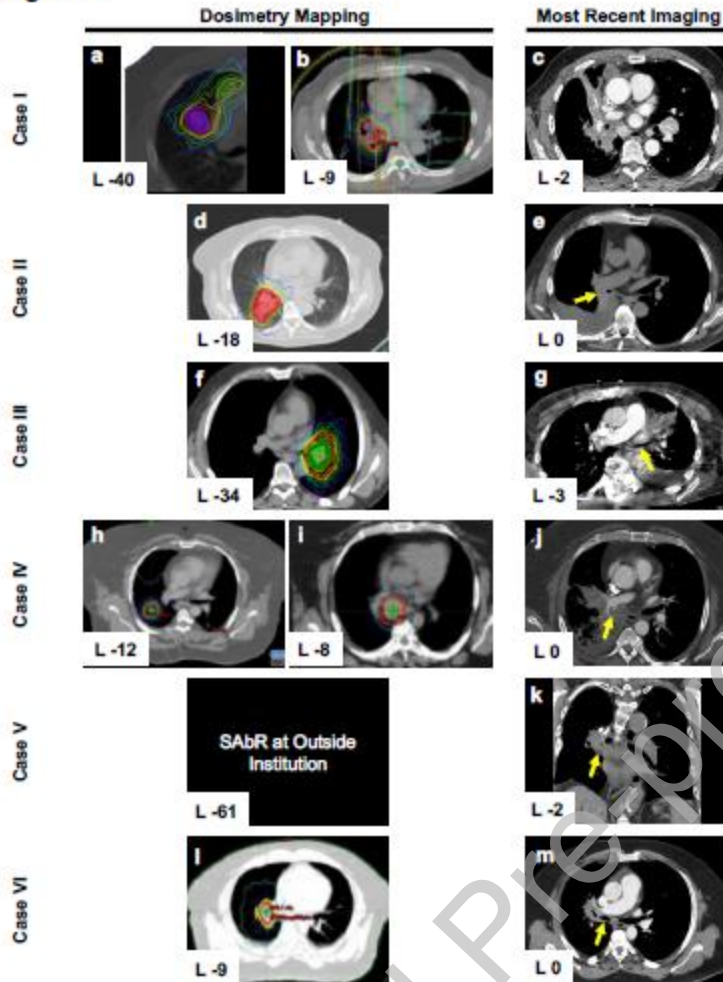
Integrated SABR dosimetry mapping and chest imaging preceding massive hemoptysis. Axial and coronal images of the cases with time in months from image to development of life-threatening hemoptysis (insert [L-months]). *Case I.* (a) Dosimetry mapping of planned SABR for 1.7cm right lung nodule and 2.7cm mediastinal lesion. (b) Dosimetry mapping for planned SABR to 2cm right hilar mass. (c) CT chest with IV contrast 2 months prior to LTH showing right bronchial obliteration and endobronchial lesions. *Case II.* (d) Dosimetry mapping of planned SABR for a 4.8cm right infrahilar mass. (e) CT chest on day of LTH revealing right bronchial constriction (arrow). *Case III.* (f) Dosimetry mapping of planned SABR for 3.1cm left hilar mass. (g) CT angiogram of the chest 3 months prior to LTH showing radiation fibrosis, bronchial narrowing (arrow), and ectatic vessel formation. *Case IV.* (h) Dosimetry mapping of planned SABR to a 1.5cm RUL mass. (i) Dosimetry mapping of planned SABR to a 3.6cm subcarinal lymph node. (j) CT angiography on the day of hemoptysis revealing a 7mm pseudoaneurysm (arrow) originating from the right intralobar pulmonary artery. *Case V.* Dosimetry mapping unavailable. (k) CT chest 2 months prior to LTH revealing a bronchial mass (arrow) leading to obstruction of multiple right lung segments prompting bronchoscopy. *Case VI.* (l) Dosimetry mapping of planned SABR to a 3.3 cm R hilar mass prior to SABR. (m) CT scan with contrast on the day of LTH reveals an infiltrative-appearing mass compressing the right pulmonary artery and vein, with narrowing of multiple bronchi (arrow).
